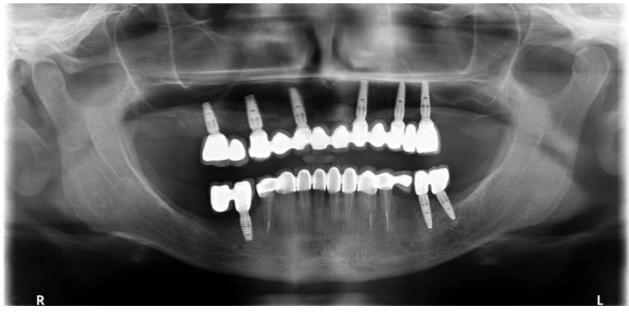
Panoramic x-ray after two and a half years recall *Rycina 12. Zdjęcie radiologiczne panoramiczne po dwóch latach i pół roku obserwacji*
